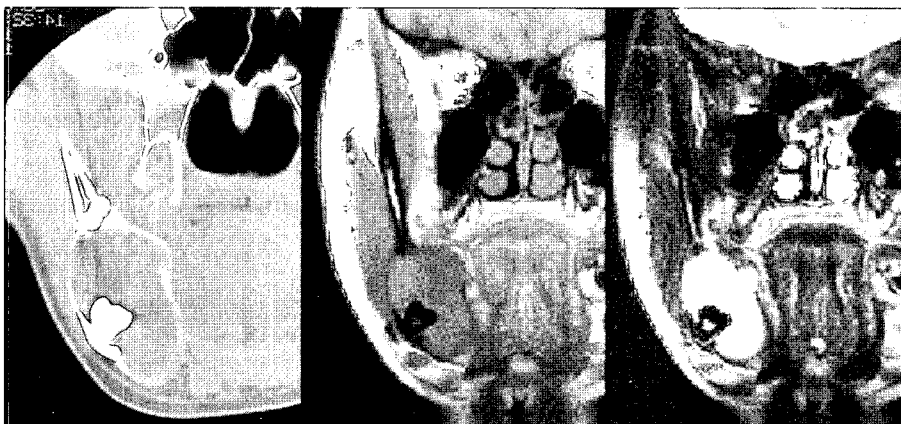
CT shows dentigerous cyst like lesion. MRI shows a lesion of homogeneous and intermediate signal intensity on T1W1 and heterogeneous high signal intensities on T2W1.
